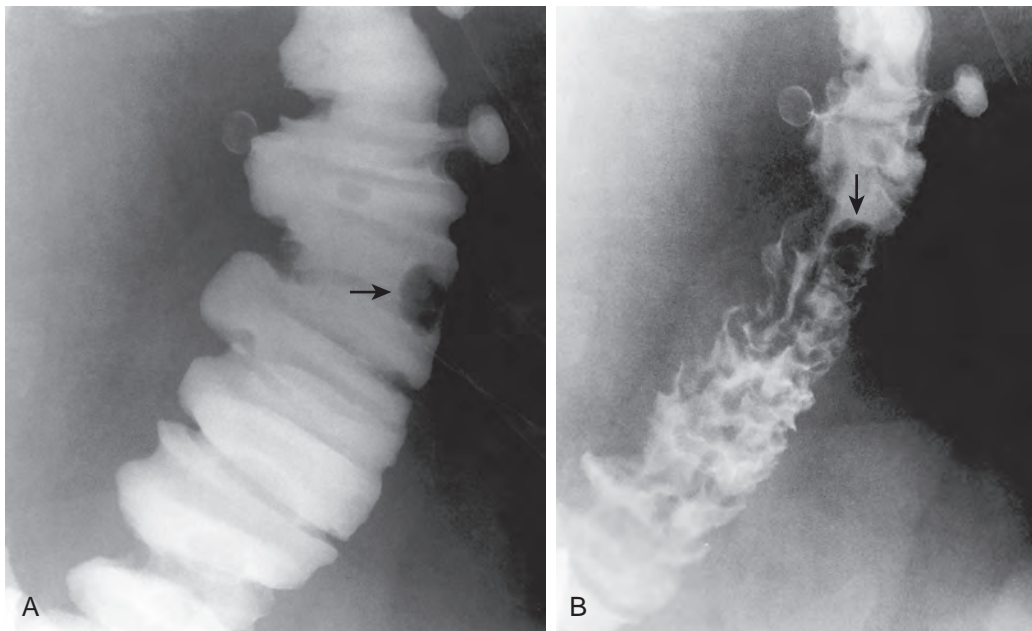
Value of postevacuation radiographs for detecting colonic polyps.
